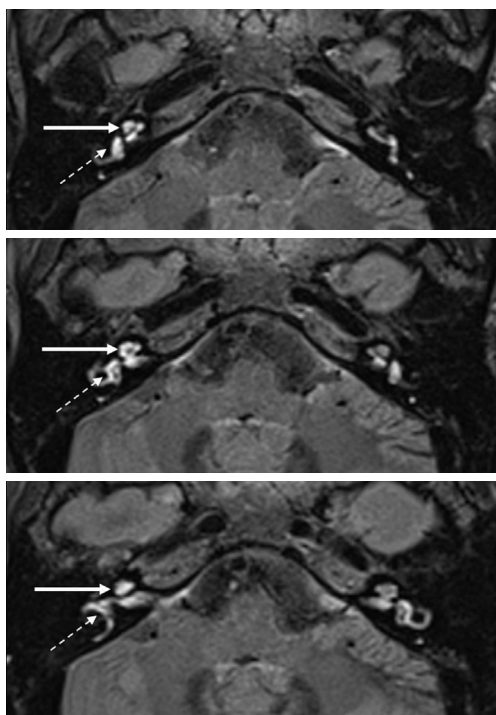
Postcontrast delayed 3D-FLAIR MRI revealed high signal intensity in the perilymph of the right vestibule and cochlea. The white solid arrows indicate the cochlea, and the white dashed arrows indicate the vestibule. 3D-FLAIR MRI, 3-dimensional fluid-attenuated inversion recovery magnetic resonance imaging.
